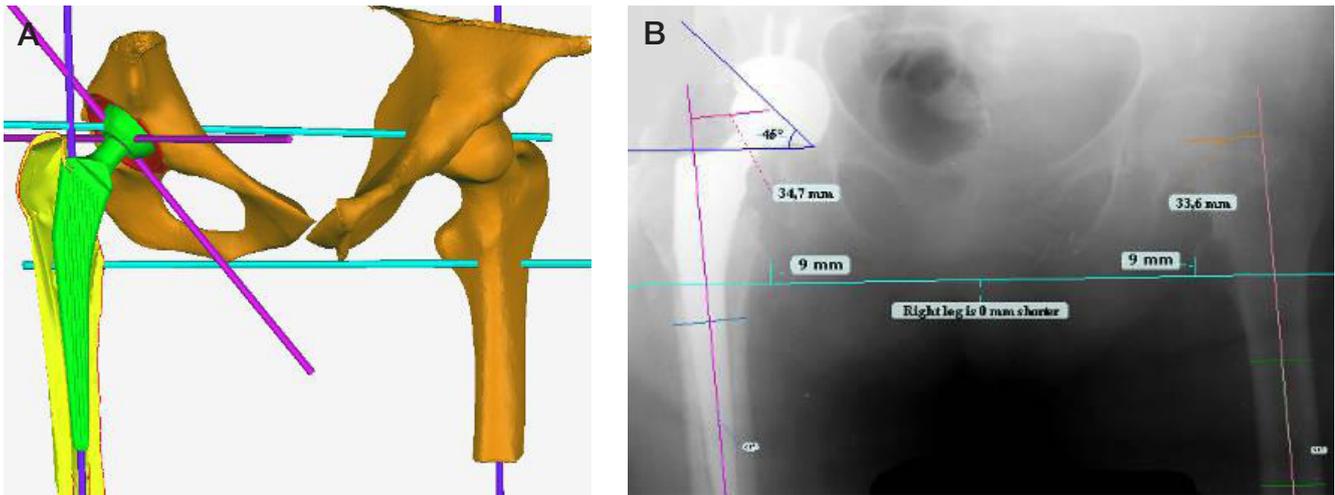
Female patient, 73 years. Comparison of the endoprosthesis component dimensions during preoperative planning based on volumetric modeling performed before and after hip arthroplasty. A. Volumetric model of the right hip joint with virtual installation of the endoprosthesis components (planned size of the acetabular component — 52, femoral component — 6). B. Survey x-ray image of the pelvis and right hip joint after installation of endoprosthesis, the dimensions of acetabular and femoral components corresponded to the planned dimensions
